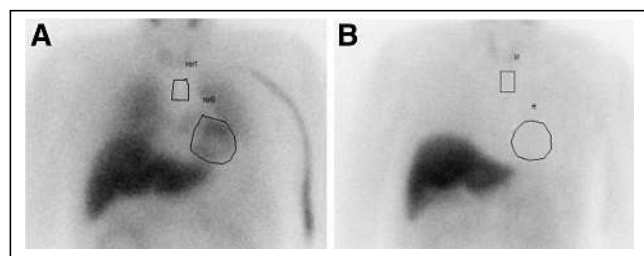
Cardiac ^{123}I -MIBG scintigraphy interpreted as normal on visual assessment by both reporters (A), and study interpreted as abnormal by both reporters (B). HM ratios were 2.3 and 1.1, respectively, on delayed-phase images. H = heart; M = mediastinum; ROI = region of interest.
